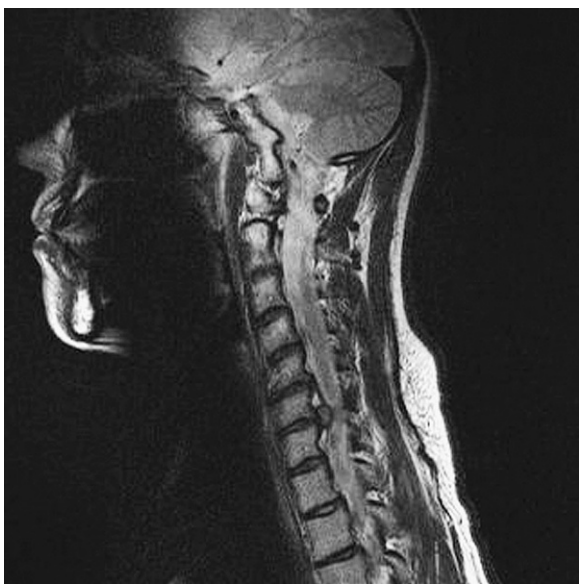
Cervical disk herniation and anterior cervical discectomy and fusion (ACD & F). A 41-year-old woman presented with pain in the neck that radiated to the left hand and fingers. This sagittal T2-weighted magnetic resonance image shows a 6-mm disk protrusion at C6–C7.
